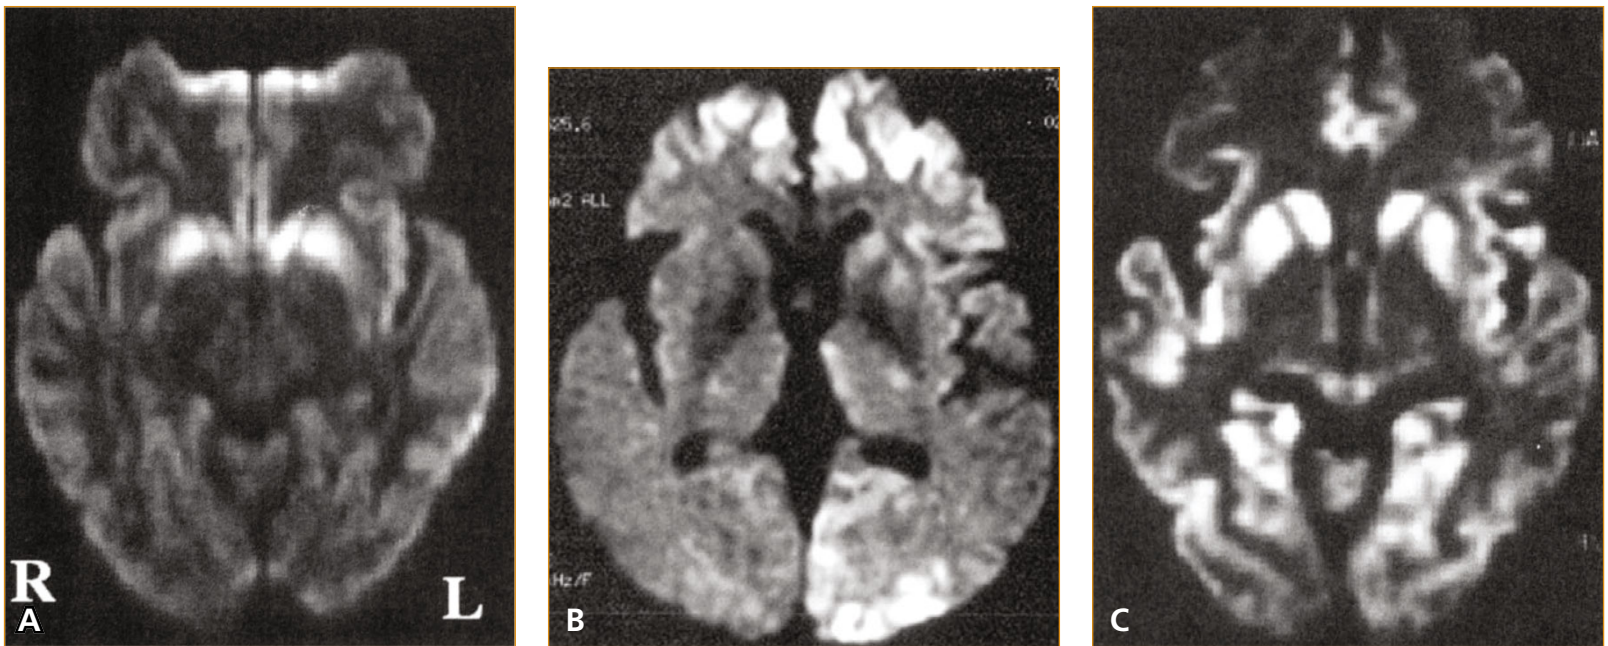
MRI of Creutzfeldt-Jakob disease. Increased signal intensity may be seen on T2-weighted, FLAIR, and diffusion-weighted imaging (DWI). Two patterns may be seen. The first is a diffuse pattern primarily seen in the basal ganglia and occasionally in the thalamus. The second is a cortical ribbon or gyriform pattern in the cortex and cerebellum. DWI appears
